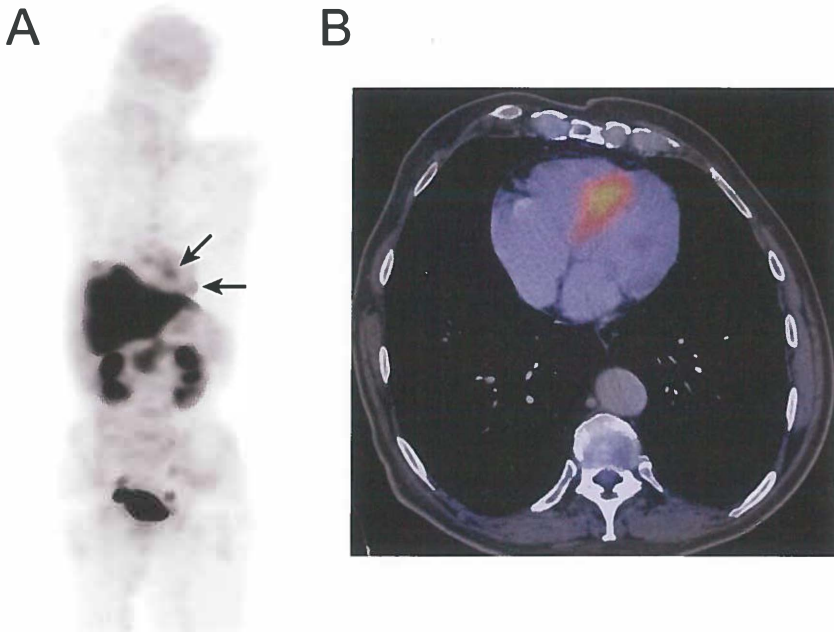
Patient 3 A. ^{11}C -5-HTP PET scan showing two cardiac metastases (arrows), both confirmed by CT scan, and extensive liver metastases. Diffuse physiological uptake in the pancreas and excretion via the kidneys, ureters and bladder. B. Fusion image of CT and ^{11}C -5-HTP PET showing one of the cardiac metastases.
